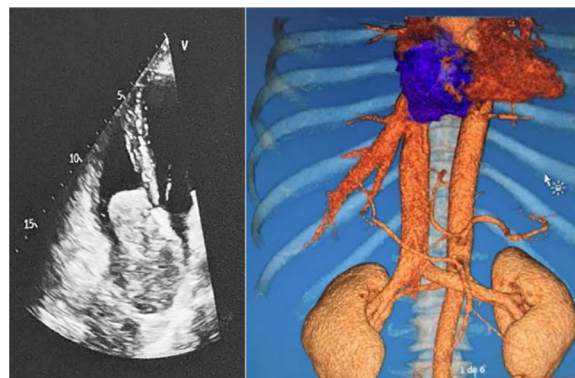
Comparison between echocardiography and tomographic reconstruction
